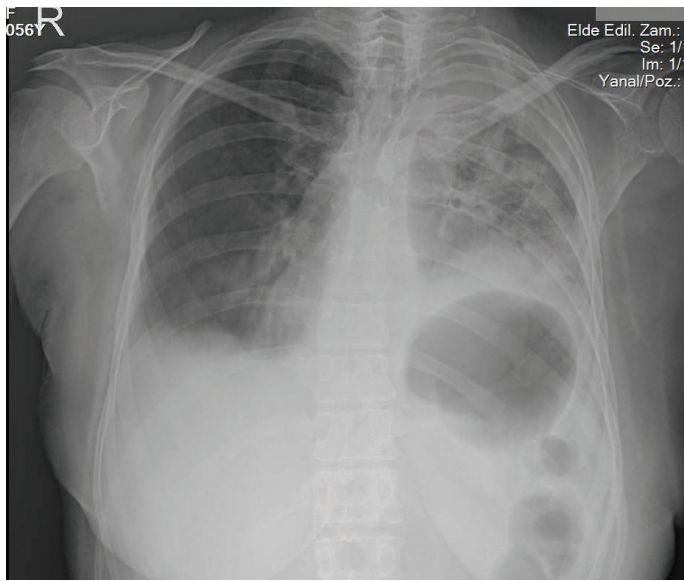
PA chest X-ray showed enlarged cardiac silhouette, blunted costophrenic sinuses, and consolidation of the left lung
